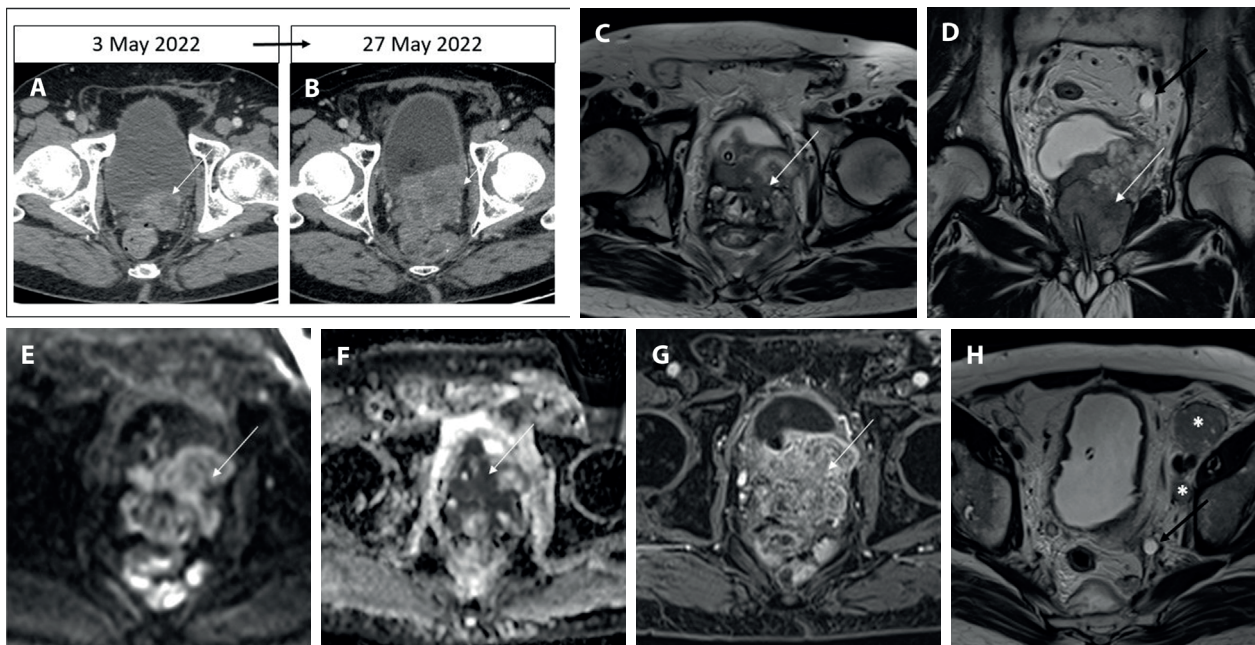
CT and MRI imaging of mBCC patient. CT scan images (in the rectangle) of the prostatic disease (arrow) progression during May 2022 (a,b). MRI scan images of the large prostatic mass (white arrow), which enveloped the intraprostatic urethra, infiltrated the mesorectal adipose tissue and determined left hydronephrosis (black arrow) (c-g). The pathologic tissue showed a heterogeneous high-intermediate signal intensity on T2-weighted images, which are not typical for adenocarcinoma prostate cancer (c, d) with high signal restriction on diffusion-weighted imaging (e), low signal on Apparent Coefficient diffusion map (f) and early and significant contrast enhancement on T1 weighted images (g). Large left iliac pathologic lymph nodes (asterisks) had the same MRI signal features (h).
